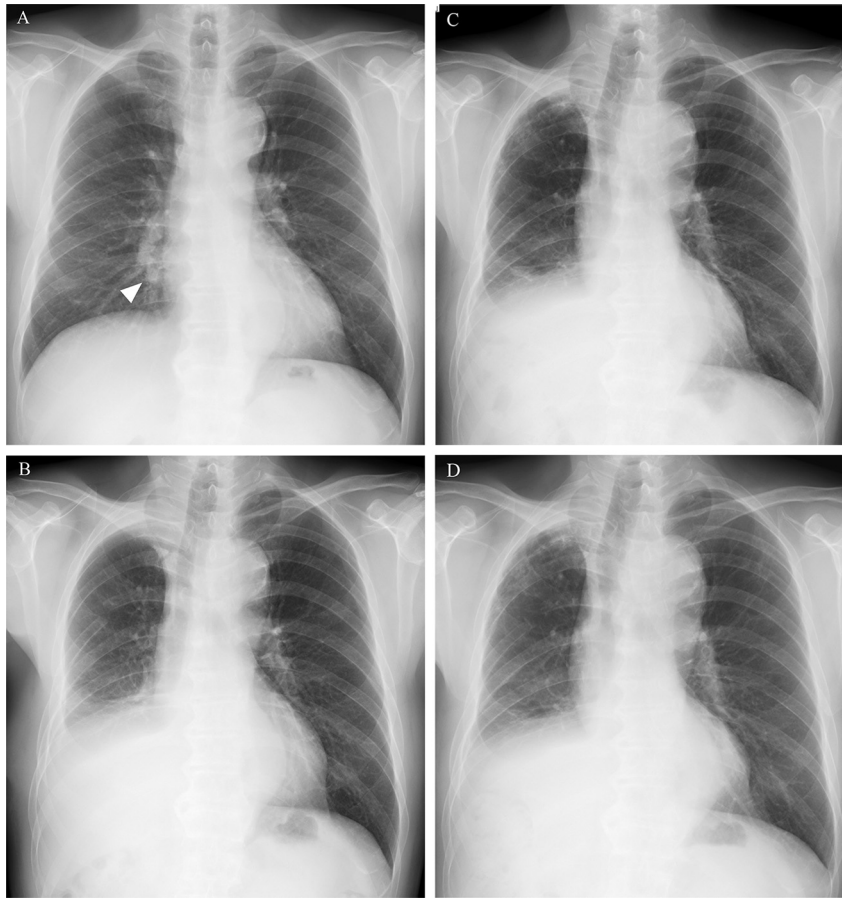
Chest radiographs. (A) A chest radiograph 20 months prior shows a nodule (arrowhead) in the right lower lung field. (B) A chest radiograph taken after a right lower lobectomy 18 months before the consultation day shows no abnormality in the residual lung on the operative side. Compared with Panel B, chest radiographs on the consultation day (C) and 2 months after the completion of treatment with praziquantel (D) show no change.
